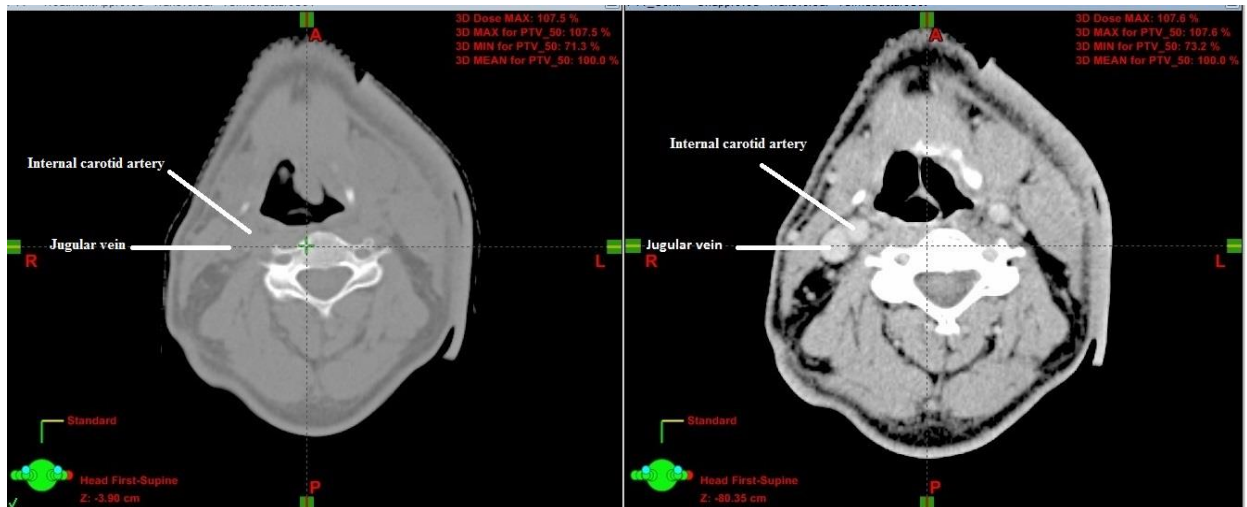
Blood vessels in CT scans before (left) and after (right) administration of contrast material
